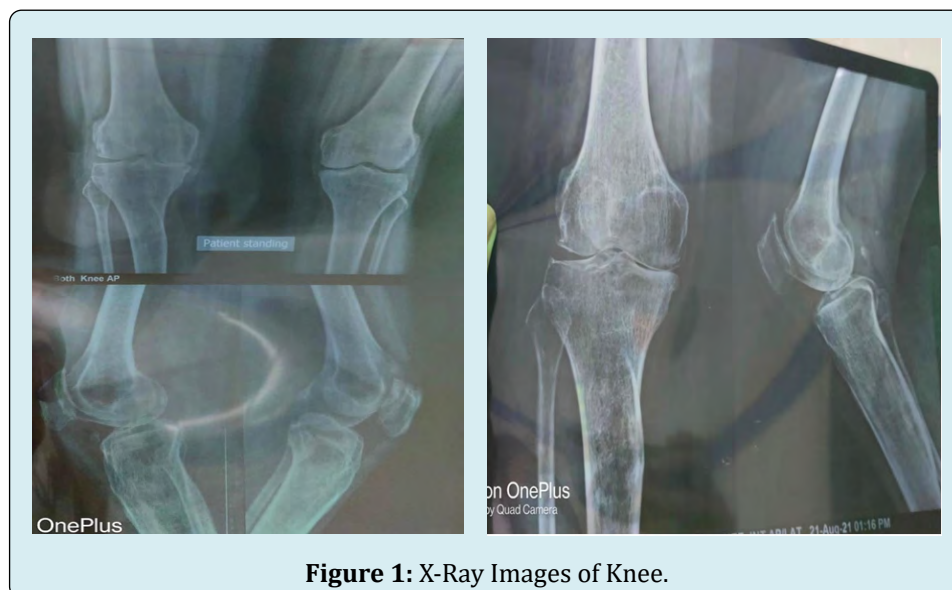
X-Ray Images of Knee.
